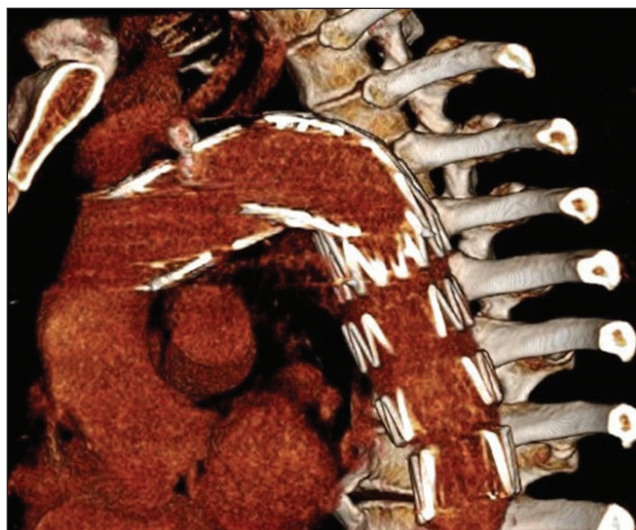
Three-dimensional reconstruction of a CTA in a patient with in situ laser fenestration of the LCCA.
